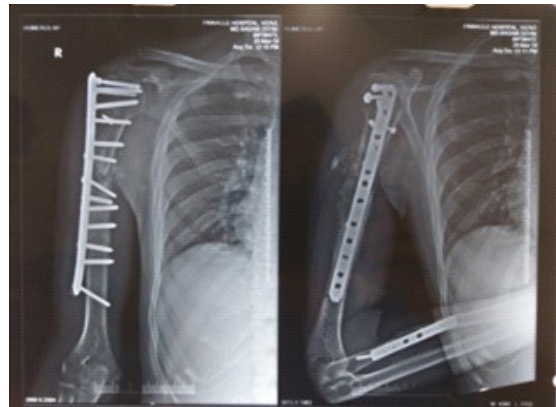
Two months postoperative radiograph
